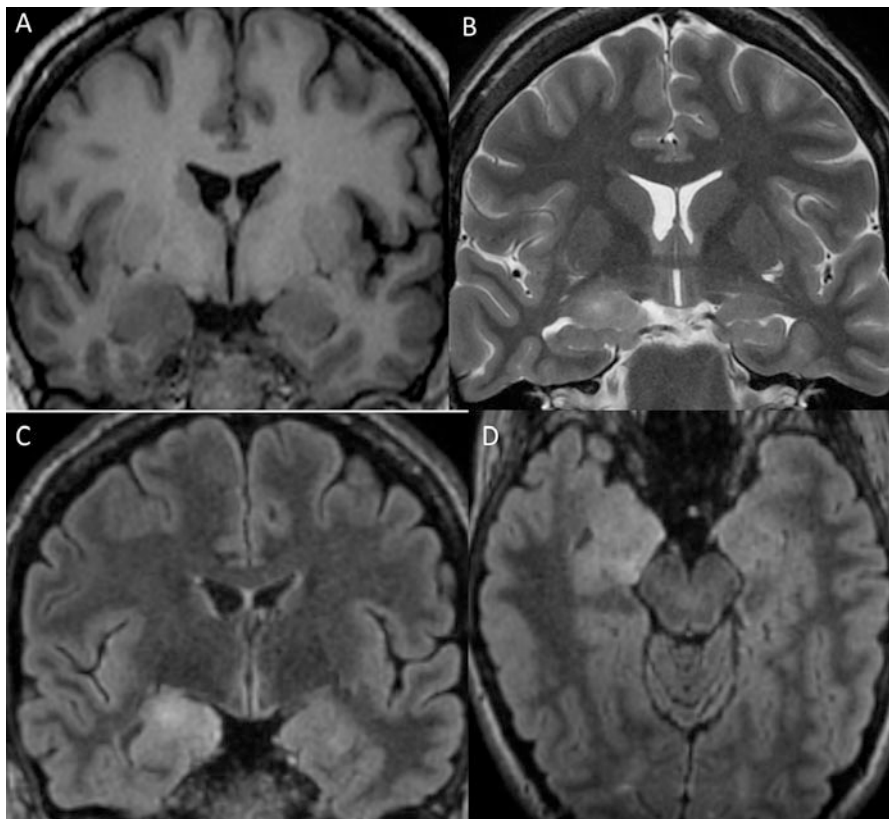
“Dysplastic” form of a right amygdalo-hippocampal DNET, hardly visible on coronal T1 (a), with a simple gray-white matter smoothing, in slight hyper signal on coronal T2 (b), coronal (c), and axial (d) FLAIR
